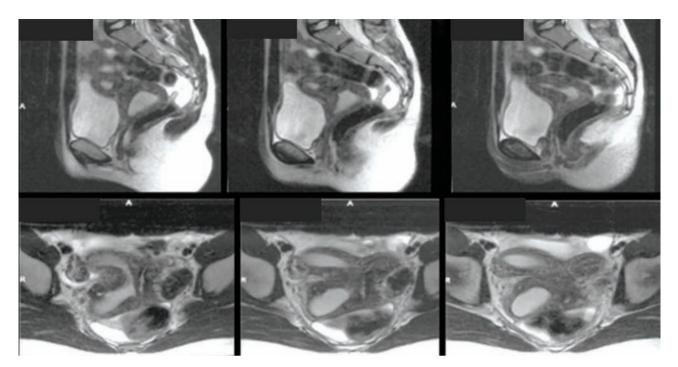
Magnetic resonance imaging of a septate vagina with hematocolpos and hematometra on the right side
